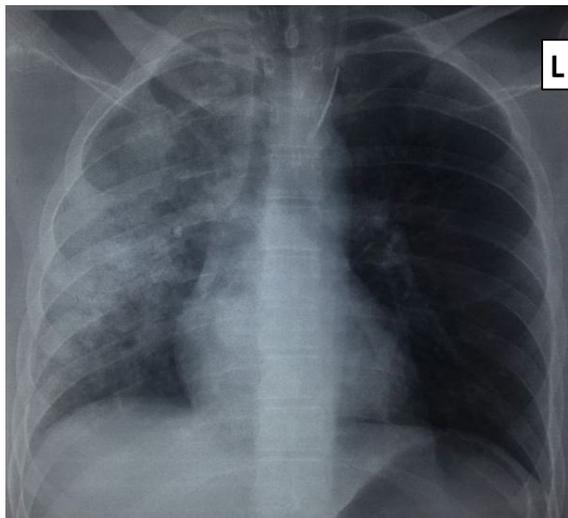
The X-ray of the lungs and heart showing bilateral nonhomogeneous shading dominantly on the right side.
